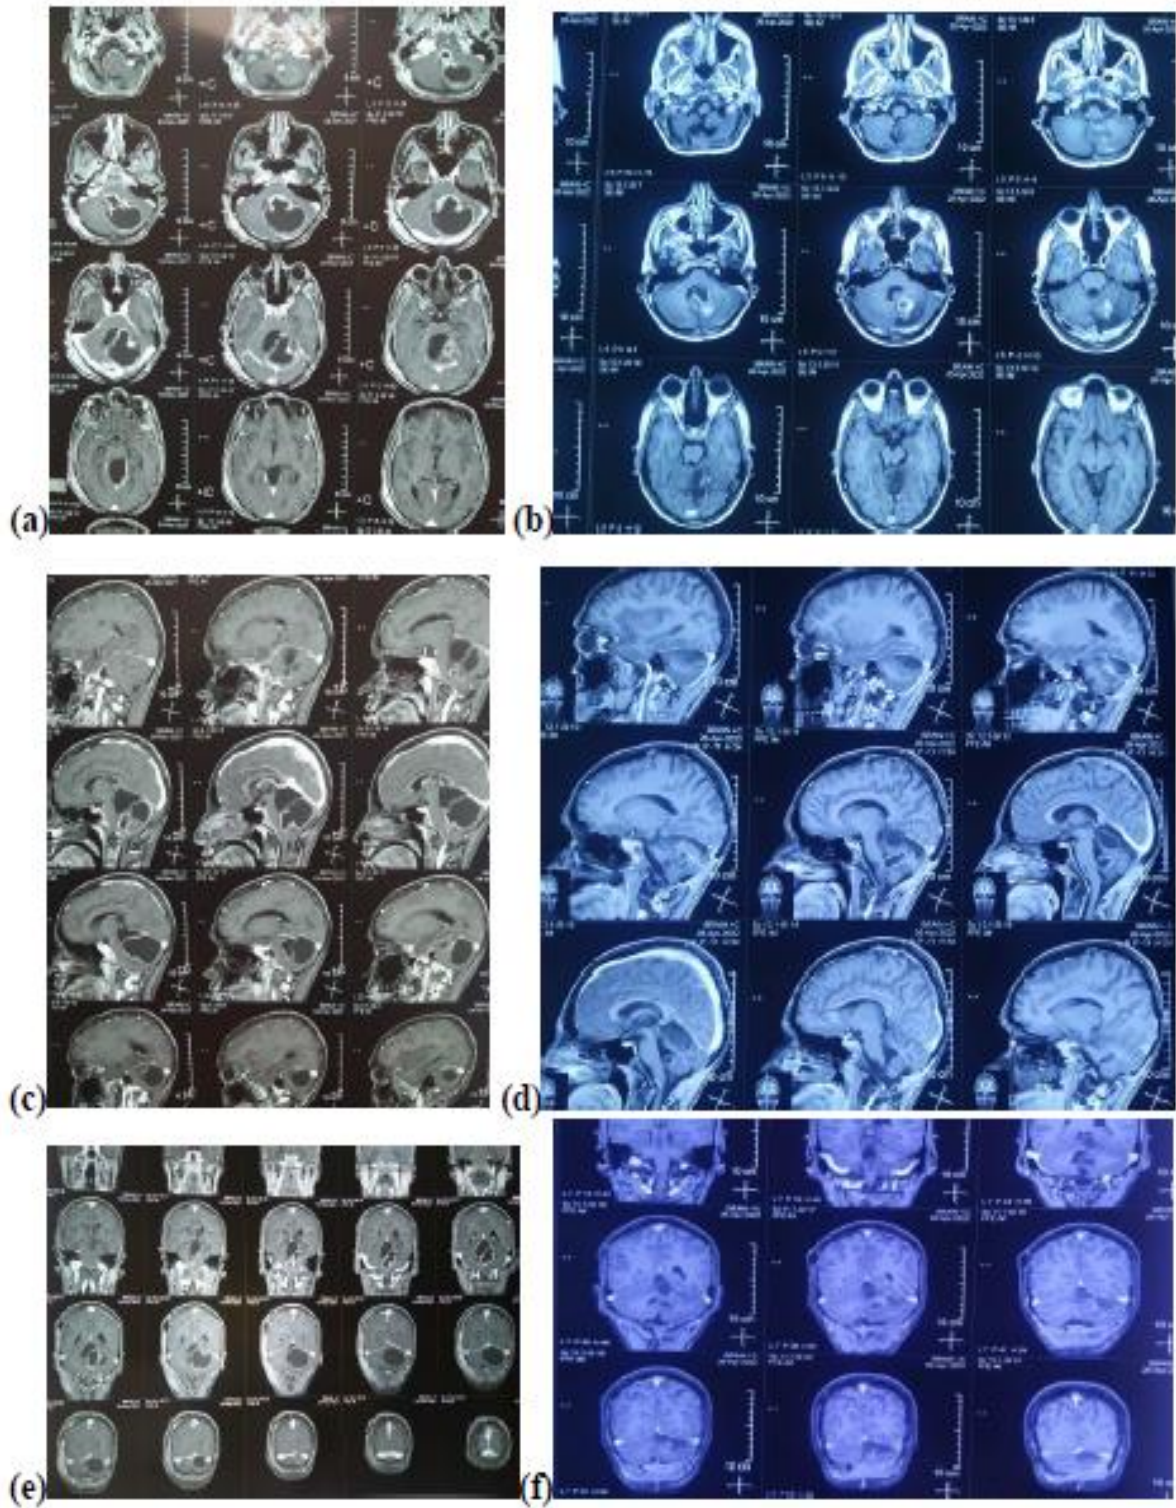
MRI brain with contrast preoperative and 6 months postoperative: (a) preoperative axial view, (b) postoperative axial view, (c) preoperative sagittal view (d) postoperative sagittal view (e) preoperative coronal view (f) postoperative coronal view.
